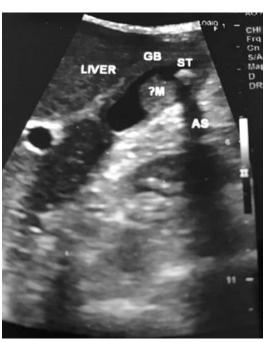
US shows an intraluminal polypoidal lesion—this can be further evaluated with CT, high-resolution US (HRUS), or endoscopic US (EUS)
